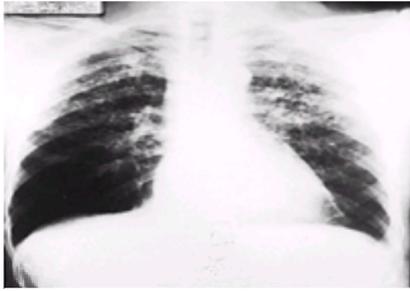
Chest radiograph of simple kaolinosis. Pneumoconiosis is apparent in upper and middle zones.
